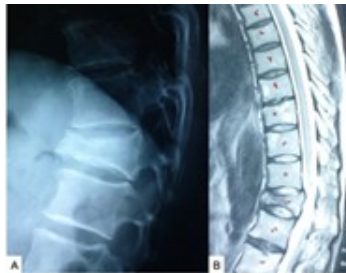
(A) X-ray and (B) MRI of dorsal spine showing relatively stable D12 compression fracture which was managed conservatively. Source: Figure by authors.
